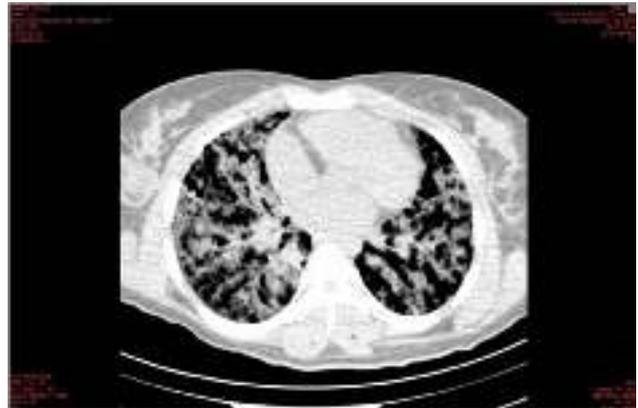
Diffuse alveolar hemorrhage in thorax CT in mediastinum view
